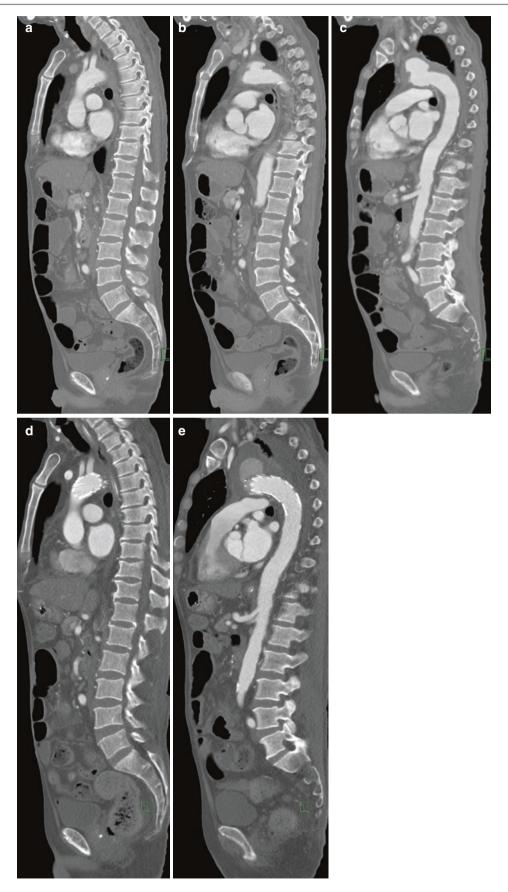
Type 2 endoleak. (a–c) Sagittal contrast-enhanced CT pre-TEVAR. (d, e) Sagittal contrast-enhanced CT post-TEVAR with endoleak. (f, g) Digital subtraction angiogram from the left subclavian
